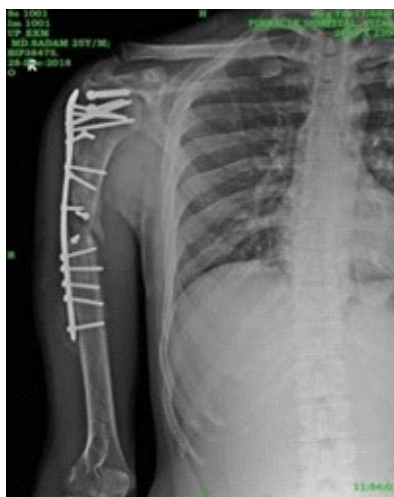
Radiograph showing refracture with bent implant.
